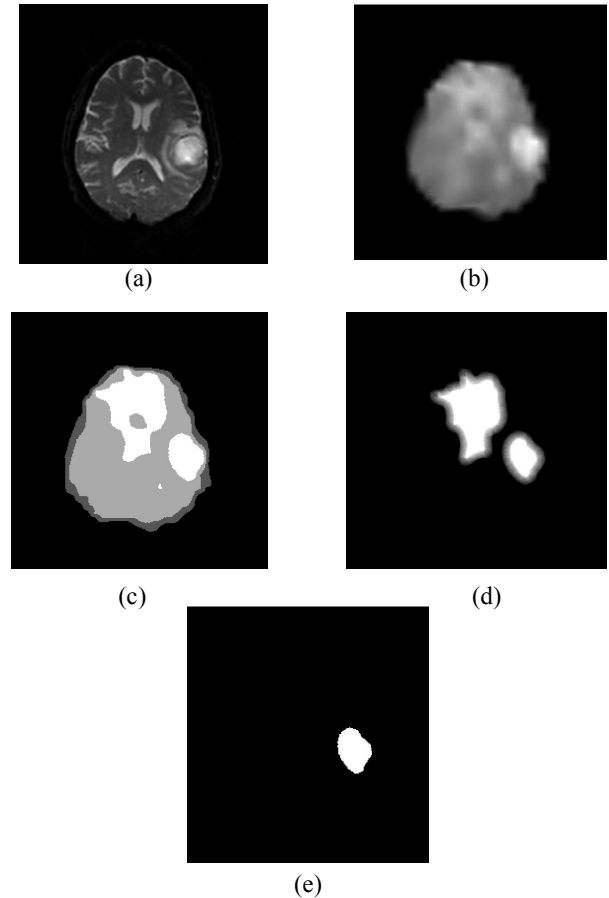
A 60 year-old woman with surgically proven left posterior temporal Glioblastoma Multiforme (GBM): a) T2-weighted image, b) Cho/Cr ratio metabolite map, c) clustering results in 4 different intensities (background=0, partial volume region around the brain=10, normal=20, cancerous=30), d) Hough transform result on the cancerous cluster, e) The detected tumor after Cho/NAA comparison of the two sides.
